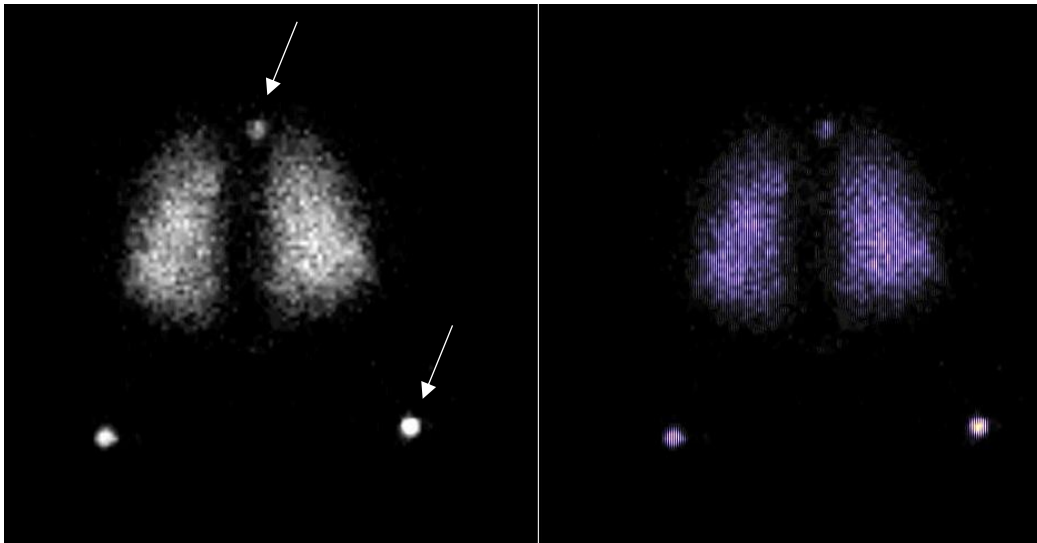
VSPECT image taken form the data set.
